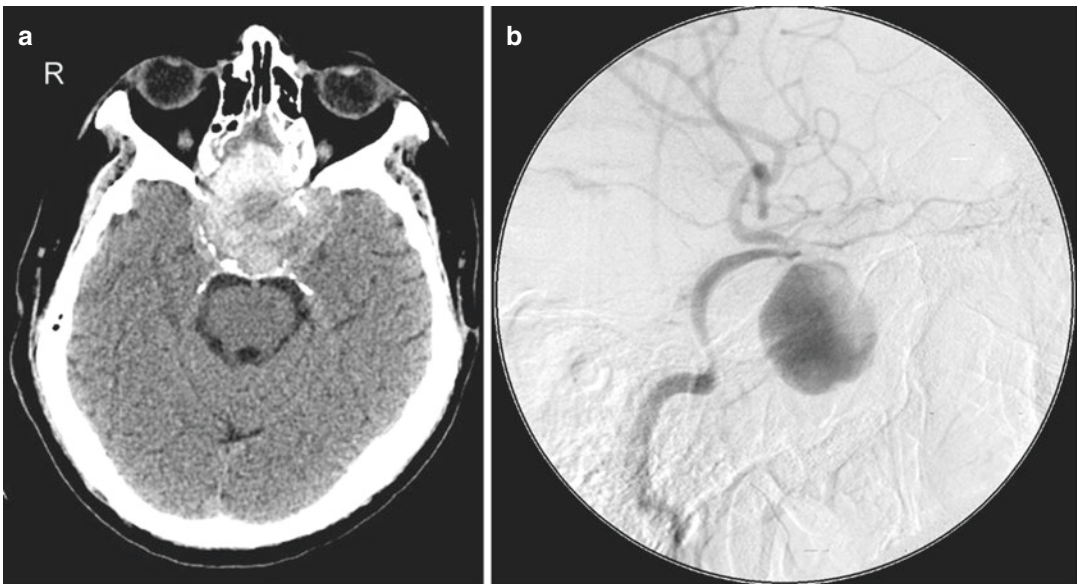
Giant pseudoaneurysm. (a) Non-contrast axial CT image shows a large mixed low and high attenuation suprasellar mass. (b) Corresponding catheter cerebral angiogram from a selective left ICA injection shows a
